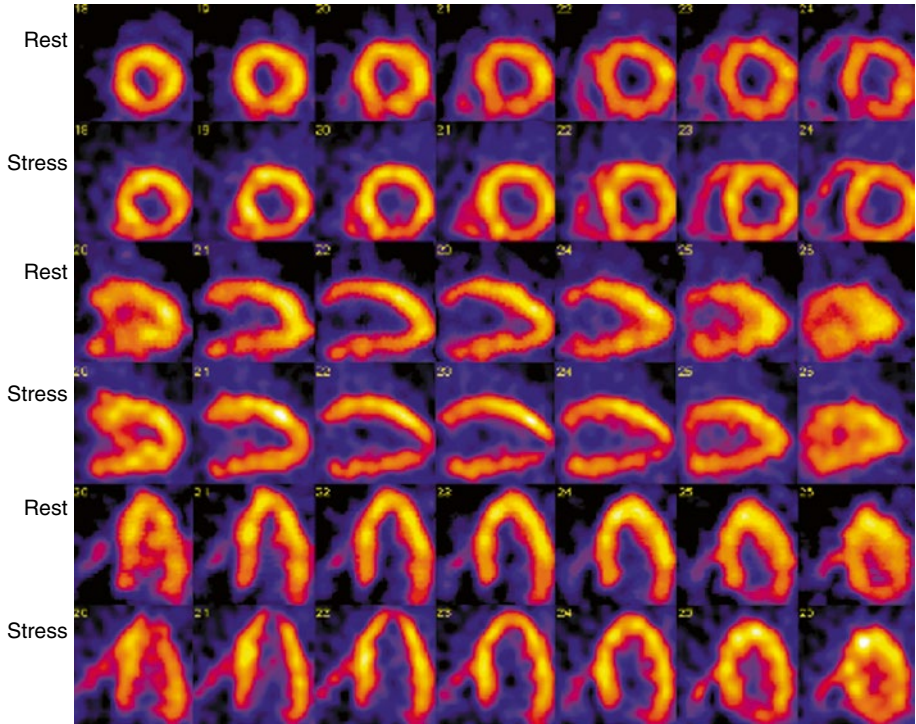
Cardiac transplant. ^{99m}Tc -sestamibi single photon emission computed tomography (SPECT) demonstrates an apical perfusion defect that is seen at stress
